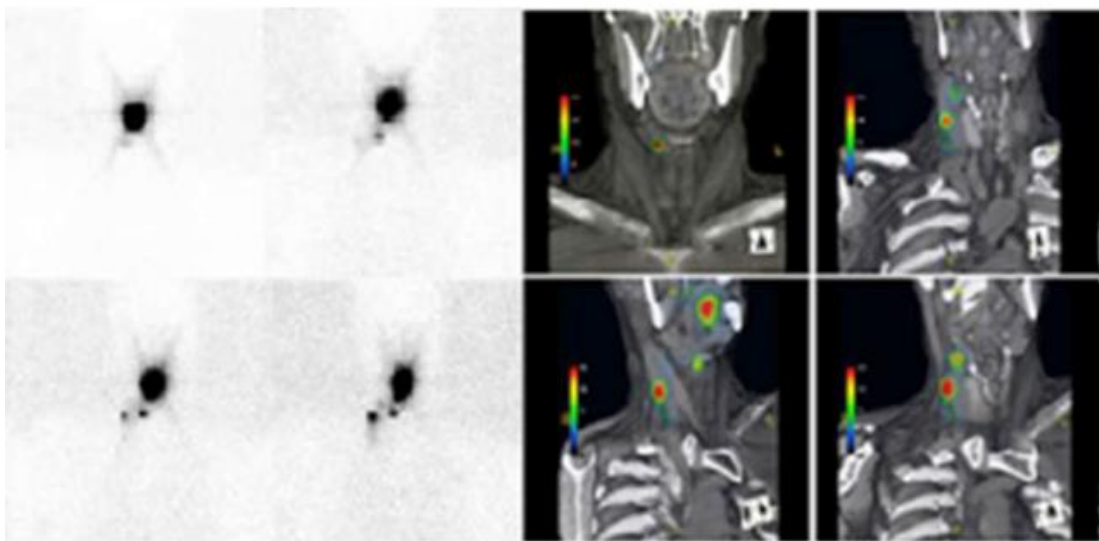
2-D conventional planar lymphoscintigraphy and fused SPECT/CT in evaluation of a patient with floor-of-mouth carcinoma and the relationship of sentinel lymph node location to anatomic landmarks, reproduced with permission [37].
